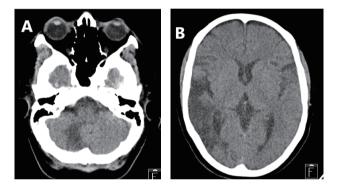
Axial view of brain CT scan without contrast showing a new infarction in right cerebellar hemisphere (A) and a remote hypodensity in the right temporoparietal region (B).
